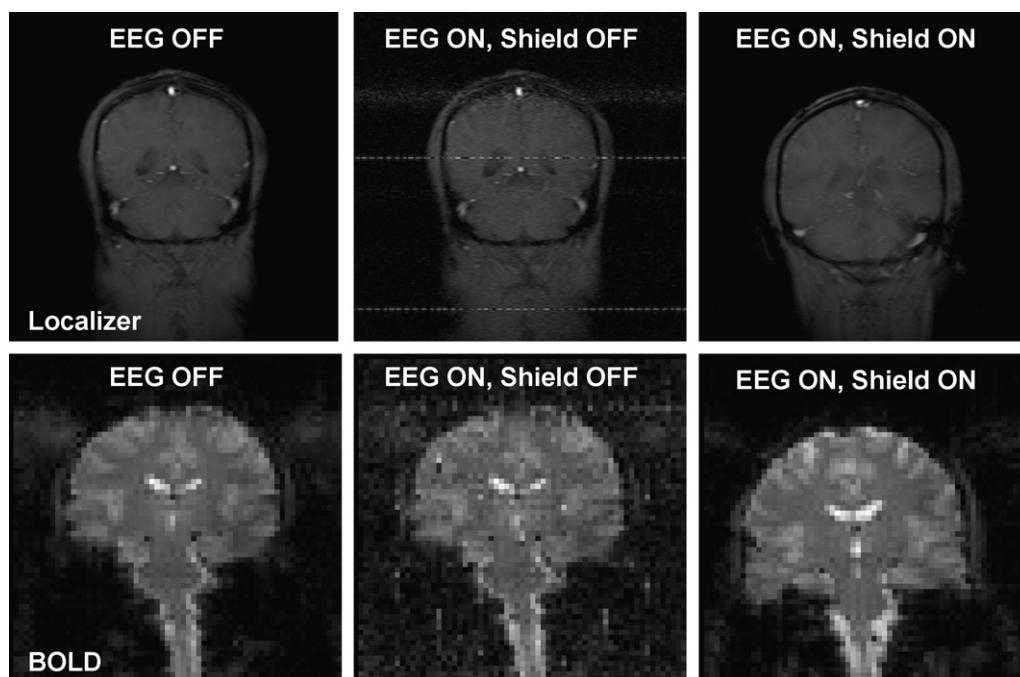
Effectiveness of RF shielding system for HF-1 amplifier and data acquisition units (3 T). Images taken without shielding (middle column) show a drastic reduction in image quality compared to normal MR images (left column) due to noise from digital processes within the data acquisition unit. When the shielding enclosure is in place, the background noise returns to nominal levels (right column).
